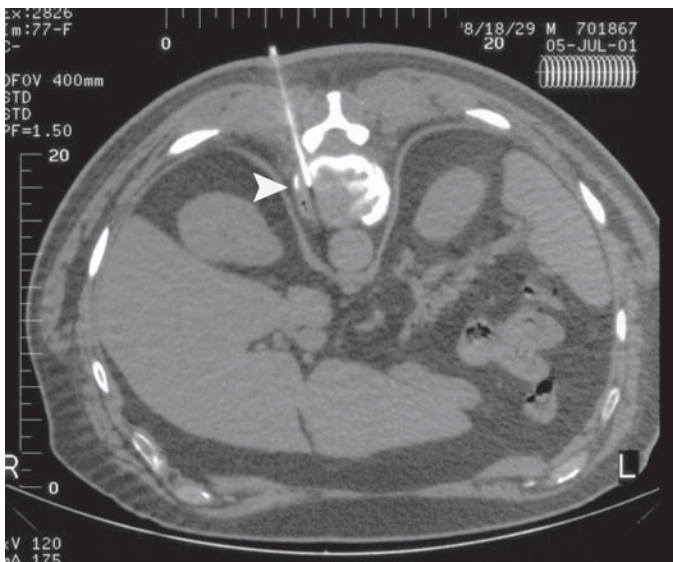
Biopsy techniques. CT-guided direct posterolateral approach.
